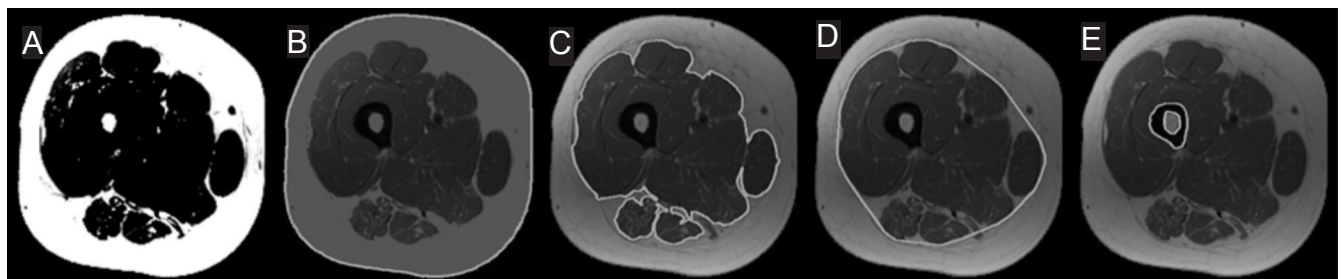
Magnetic resonance imaging (MRI) semi-automated segmentation. (A) A high pass filter. (B) The outer SAT border used to quantify the TC CSA. (C) Segmentation of outer border of the muscle mass. (D) The convex hull applied to the outer border of the muscle mass to mimic fascial line. (E) Threshold segmentation of the femoral bone and bone marrow fat. TC: Thigh circumference; SAT: subcutaneous adipose tissue.
